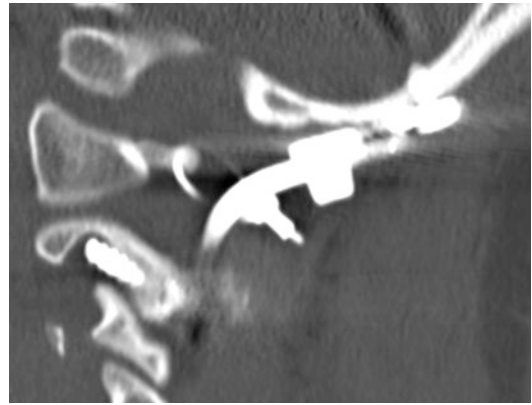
CT scan documenting malposition of a C2 pars screw with impingement into the vertebral artery
